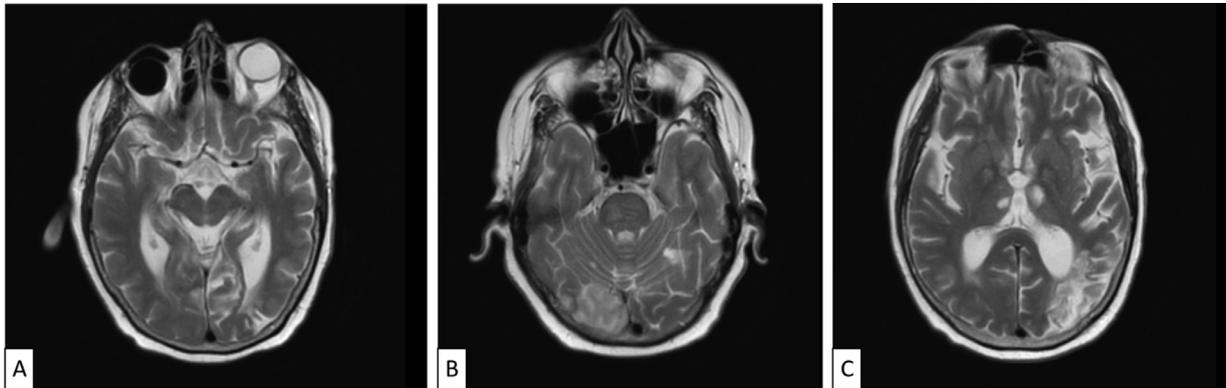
Magnetic resonance imaging shows bilateral occipital lobe infarctions. The left infarct is superior to the calcarine fissure (A) and the right infarct is inferior to the calcarine fissure (B). The patient was also found to have a remote infarct of the left parieto-occipital lobe (C).
